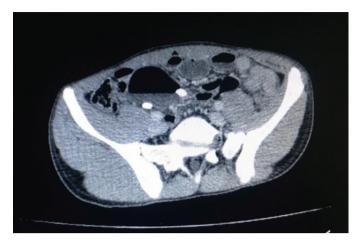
Computed tomograpy of patient
